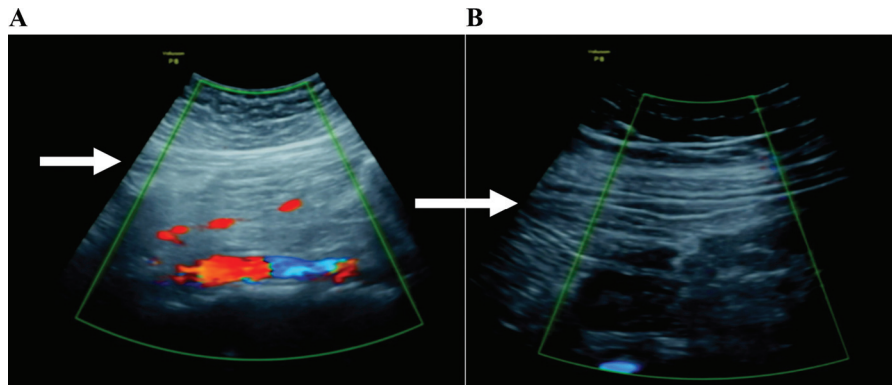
Ultrasonography before and after abdominal wall elevation device application (A) Prior to LevaLap 1.0 application. (B) After LevaLap 1.0 application. Arrow identifies peritoneal layer. No bowel visually brought into the LevaLap 1.0 dome.
